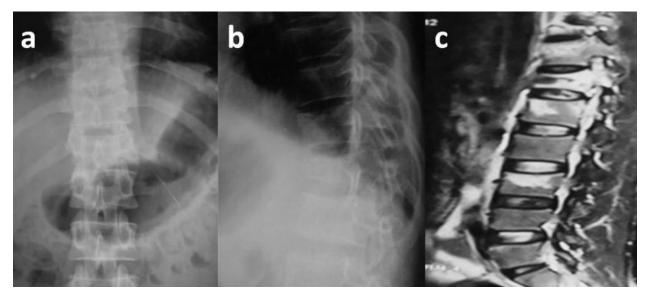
Anteroposterior and lateral radiograph of thoracolumbar spine of a 42 year old male patient showing fracture of D12 vertebra. The MRI (Image "c") also showing the compression of the spinal cord at the level of fracture.
